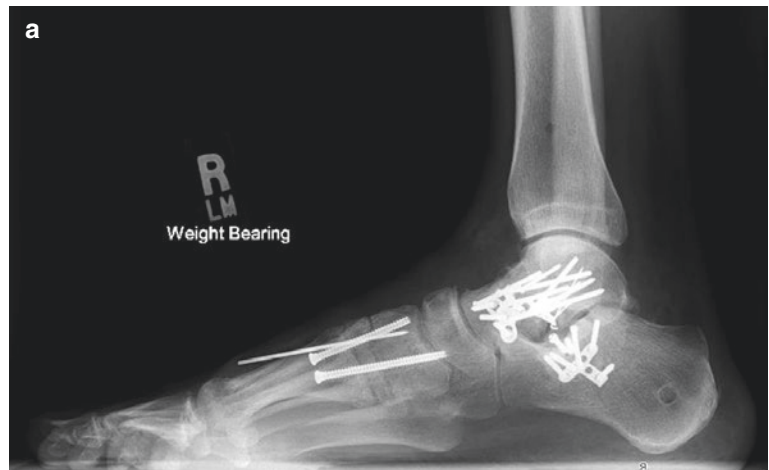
A lateral X-ray (a) and coronal CT scan (b) demonstrate a combined talar neck, lateral process talus, and sustentaculum fracture
